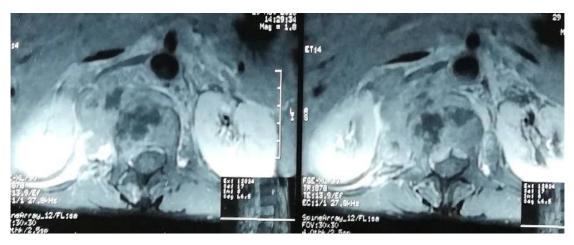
Medullary MRI showing the bone marrow infiltration of T12, L1 and L2
